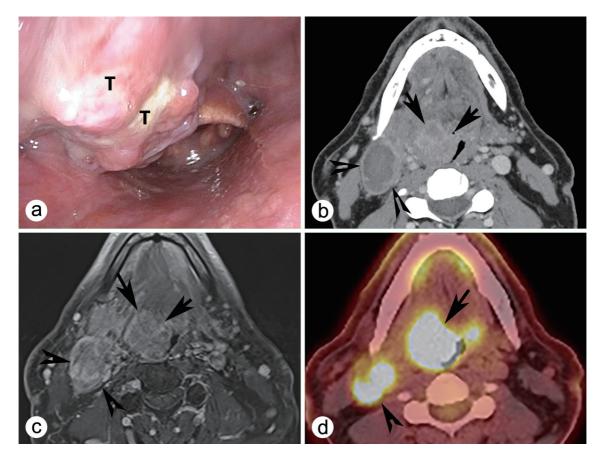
Oropharyngeal squamous cell carcinoma. (a) A 66-year-old male with a 4-centimeter mass (T) involving the left base of the tongue and oropharynx with focal ulceration. (b–d) The computed tomography scan (b, axial), magnetic resonance image (c, T1, axial), and positron emission tomography/computed tomography scan (d, axial) showing a hyperintense base of the tongue lesion that extends into the floor of the mouth (arrows) and left neck level 2 lymph node metastasis (arrow heads).
